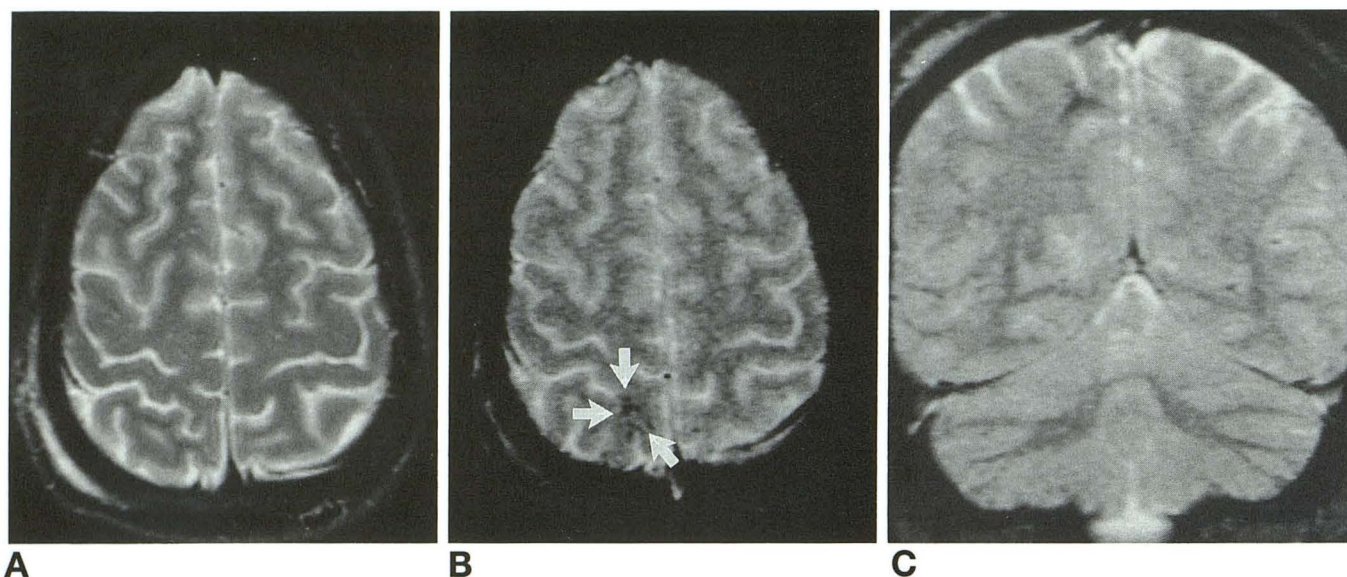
A, There is no evidence of abnormal high or low signal intensity on T2-weighted spin-echo MR of the brain of a 20-year-old man obtained within 24 hours after mild head injury caused by an automobile accident. Head CT (not shown) was also normal.
